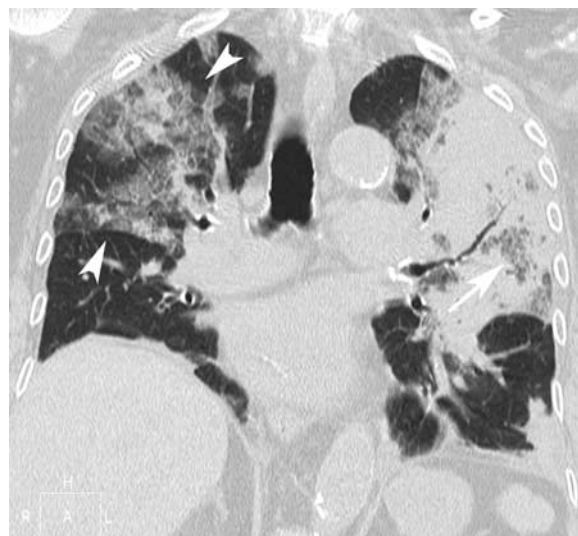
Legionella pneumophila* pneumonia. Coronal CT scan of a 36-year-old man with *L. pneumophila* pneumonia shows ground-glass opacities in the right upper lobe (arrowheads).
